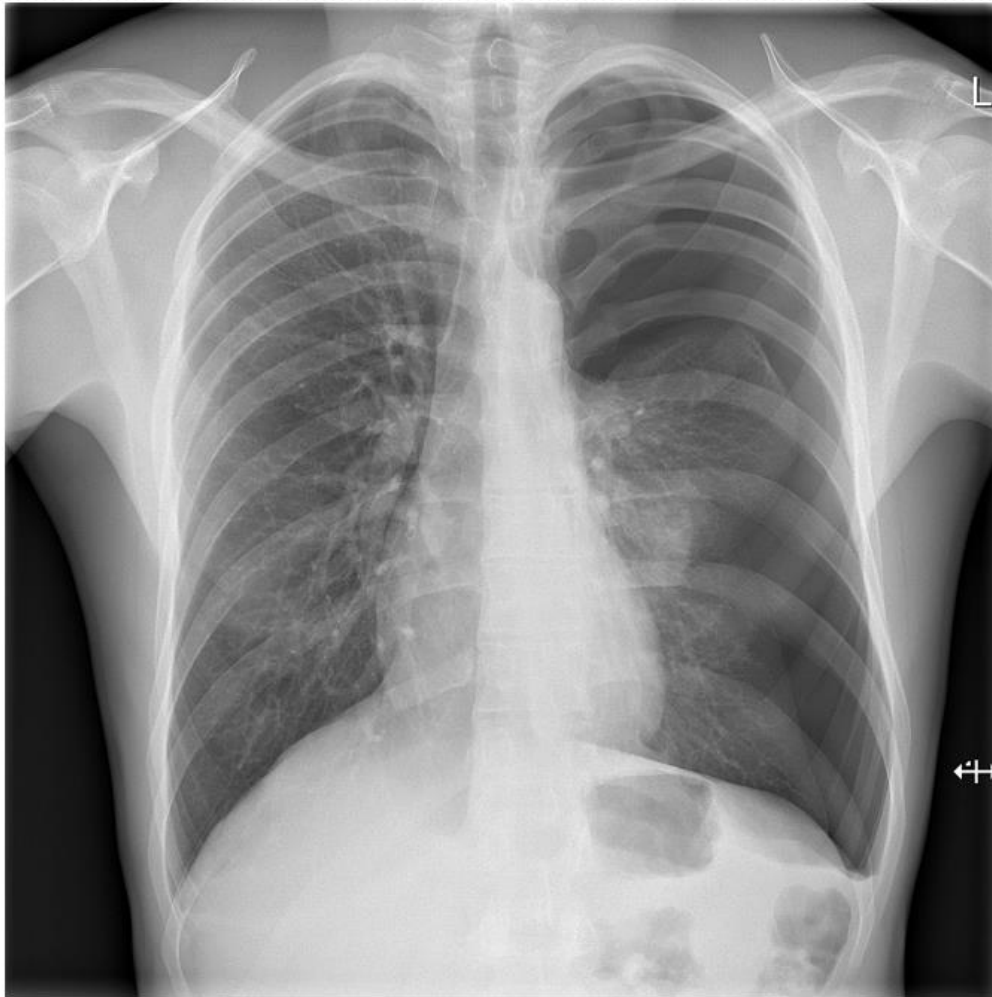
A chest X-ray showing a left-sided primary spontaneous pneumothorax.
